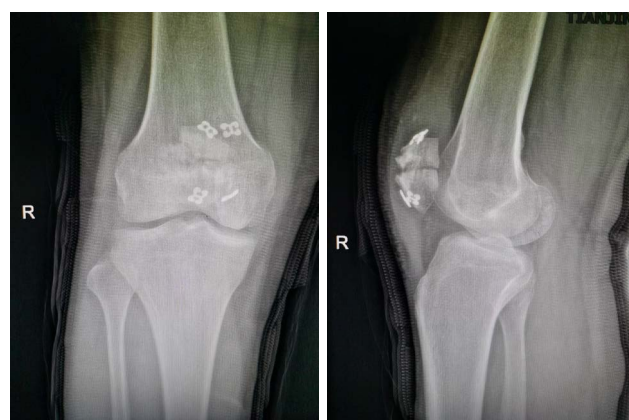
Postoperative radiograph of double button plate fixation (2 days).
